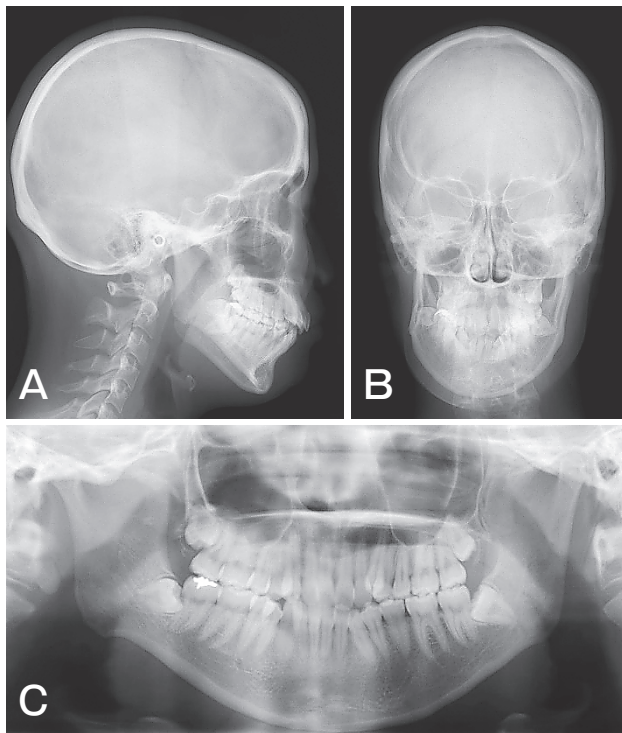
Pretreatment cephalograms and a panoramic radiograph. (A) Lateral cephalogram, (B) posteroanterior cephalogram, (C) panoramic radiograph.
